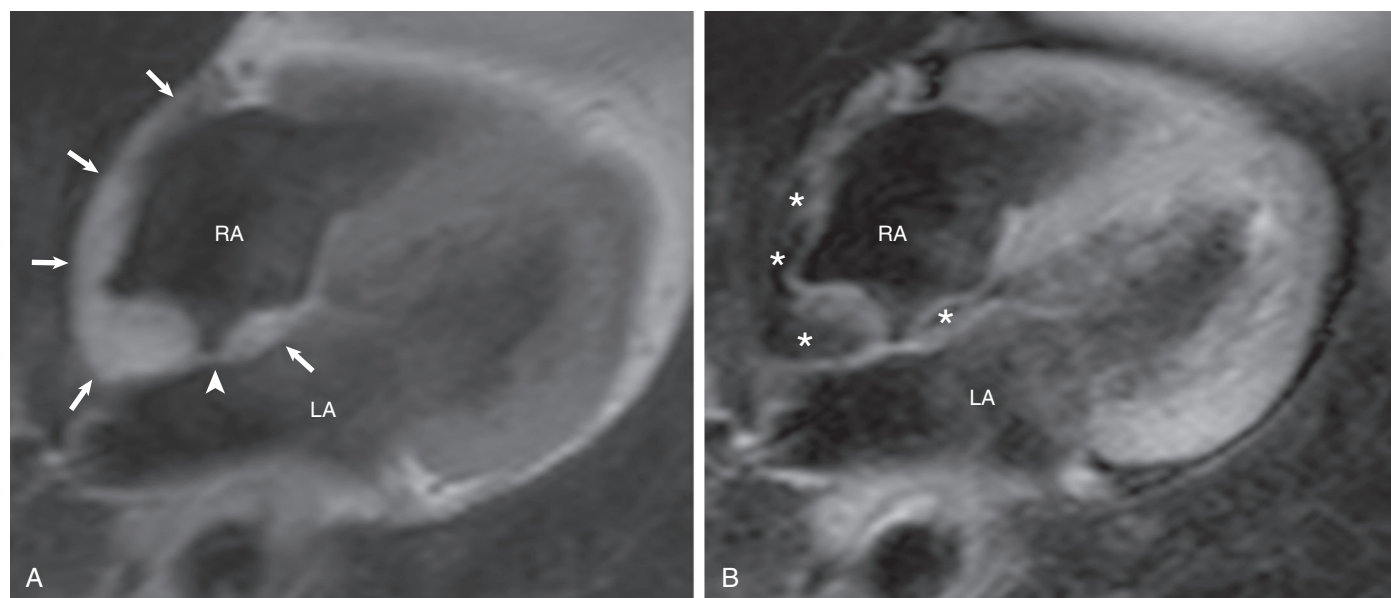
Lipomatous hypertrophy of the interatrial septum. The patient was a 78-year-old woman who was referred for evaluation of a right atrial mass. A, T1-weighted turbo spin echo image in the axial plane shows extensive thickening of the right side of the interatrial septum and of the right atrial free wall (arrows), sparing the fossa ovalis (arrowhead). The high signal intensity is suggestive of a right atrial lipoma or lipomatous hypertrophy of the atrial septum. B, After application of fat saturation in the same plane orientation, the signal from the right atrial mass is completely nulled (asterisk), confirming its lipomatous nature and the diagnosis of lipomatous hypertrophy of the atrial septum. LA = left atrium; RA = right atrium. (Courtesy François-Pierre Mongeon, MD, SM, FRCPC, Montreal Heart Institute, Université de Montréal, Montreal, Quebec, Canada.)
